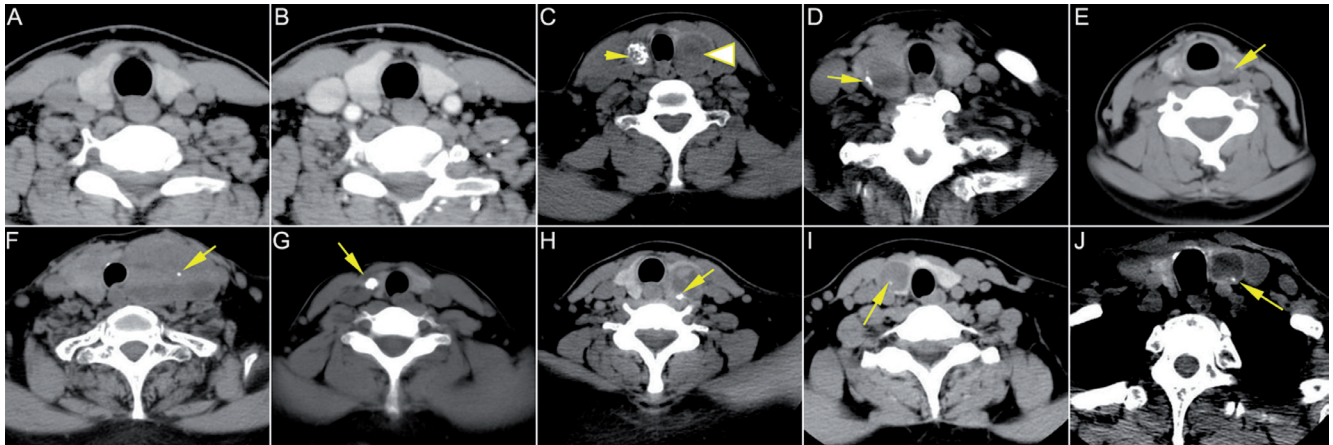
CT images of the thyroid nodules.
